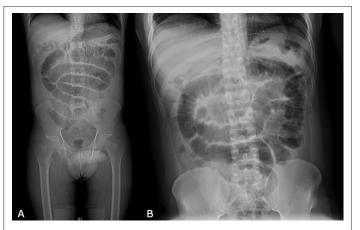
(a) Body X-ray; (b) Abdominal X-ray. No clear drug package is seen in both images.
